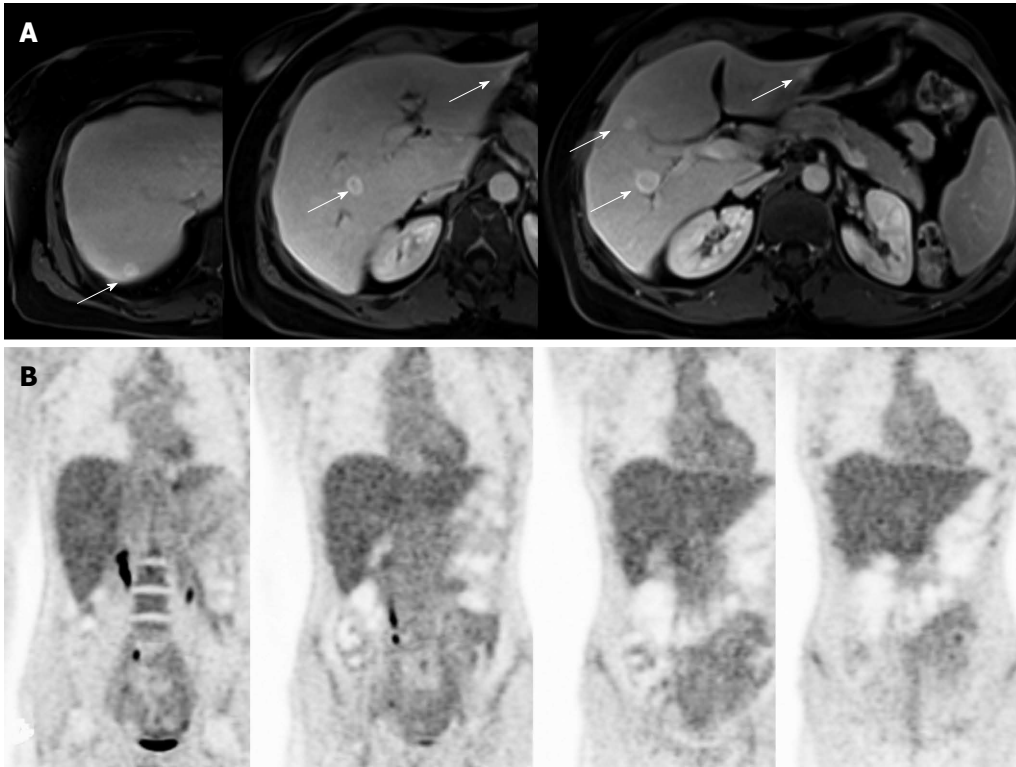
Radiological imaging of case 1. A: The abdominal contrast-enhanced magnetic resonance imaging showed multiple bilateral focal liver lesions (arrows); B: The fluorodeoxyglucose-positron emission tomography scan did not show any pathological uptake of the trace.
